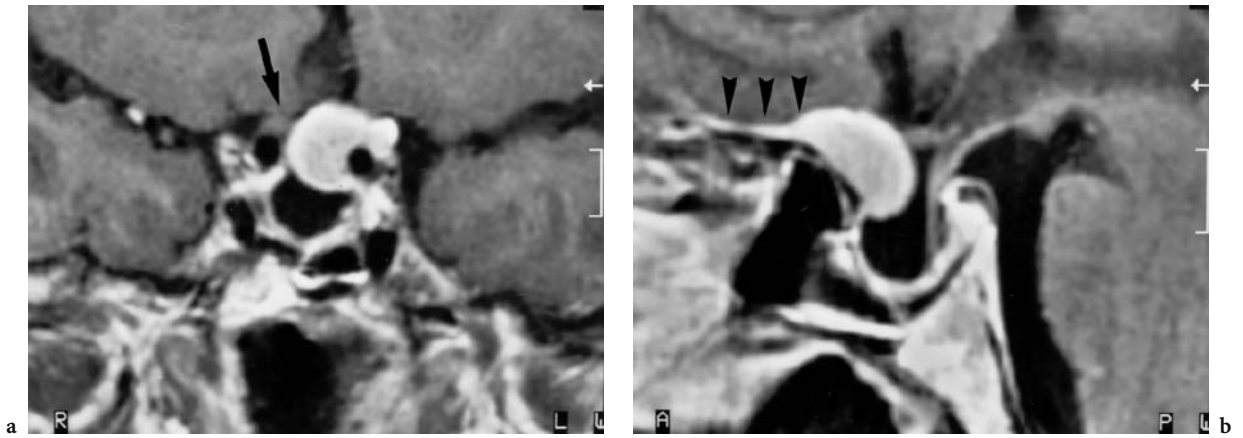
A 53-year-old woman with slowly progressing visual deficit. Diagnosis: meningioma of the tuberculum sellae. T1-weighted, contrast-enhanced MRI: a Coronal view at the level of the optic canal showing a homogeneous, sharply defined tumor of the left tuberculum sellae, encasing the ipsilateral ICA, although without diminution of the ICA diameter. No differentiation of the left optic nerve is possible because the tumor crosses the midline and reaches the right optic canal (*arrow*). b Midsagittal view with the typical meningeal „tail“ along the sphenoid plane (*arrowheads*). Empty sella as an incidental finding. (From MÜLLER-FORELL and LIEB 1995)
